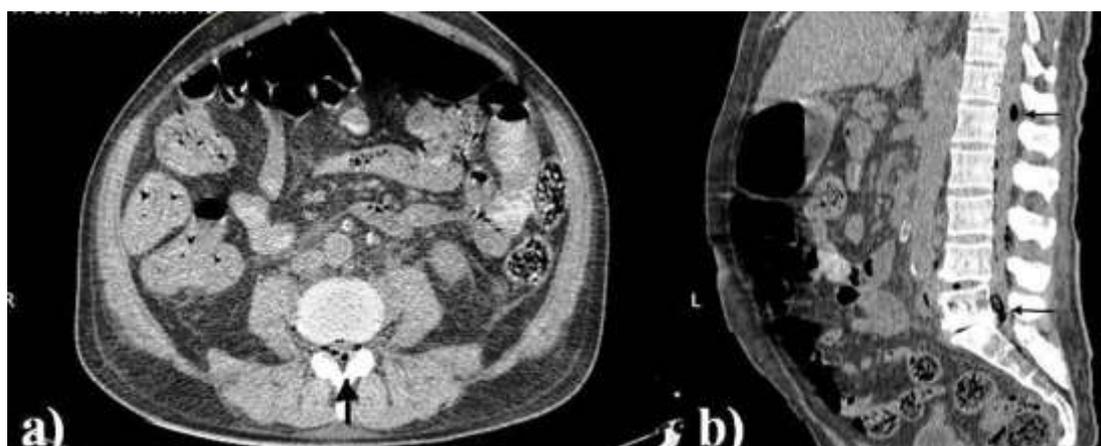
Axial and Sagittal Non contrast CT images of the abdomen showing presence of air in the spinal canal (black arrows)
